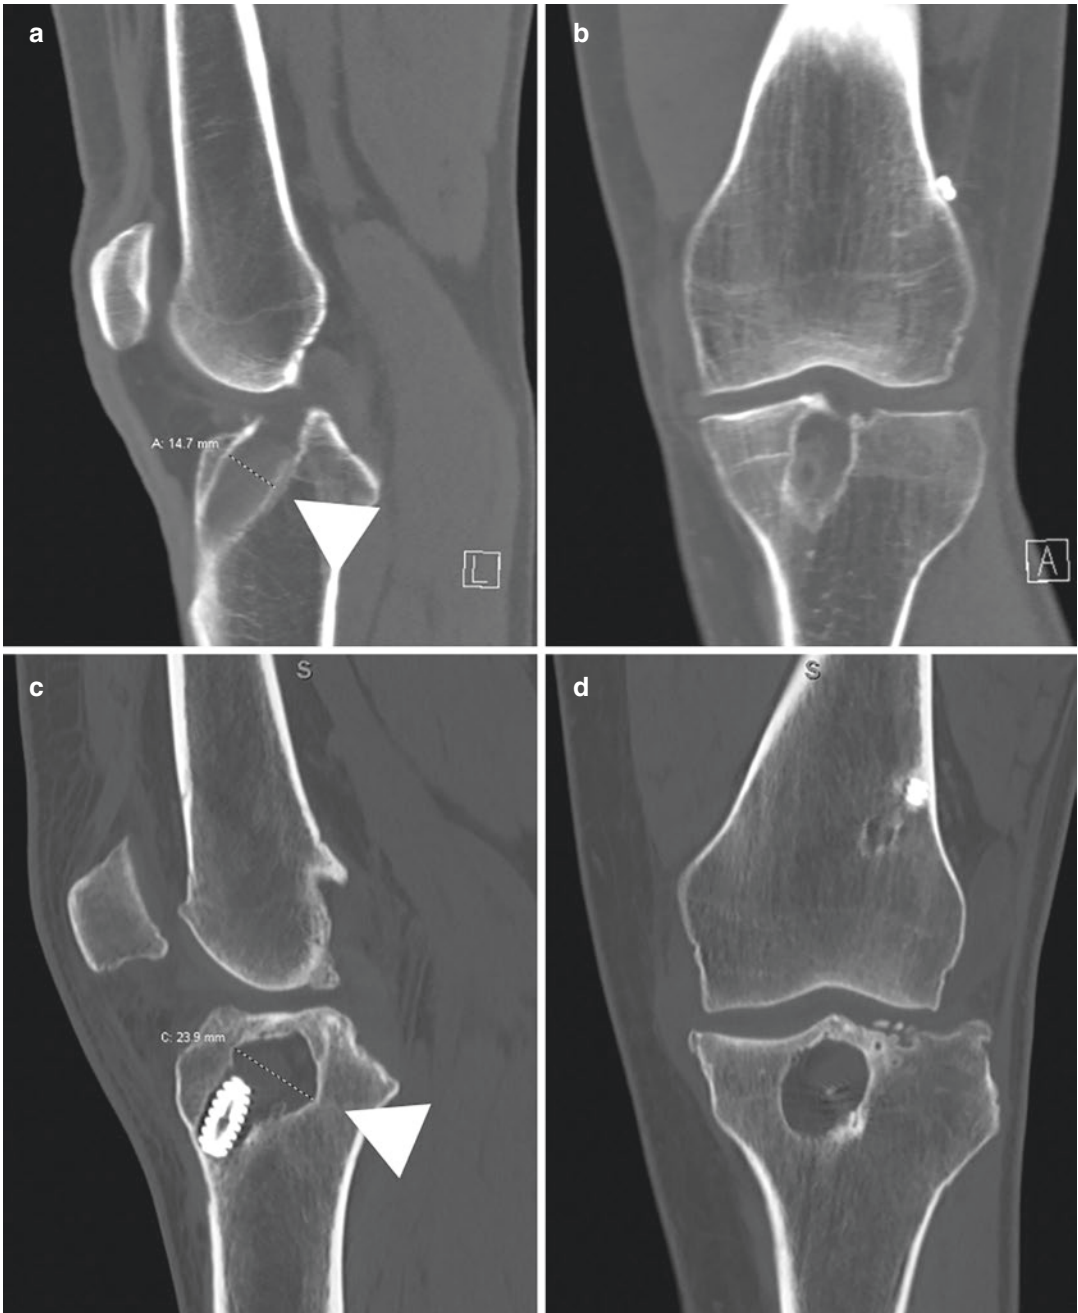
Tunnel osteolysis on CT after anterior cruciate ligament reconstruction. Sagittal (a and c) and coronal (b and d) images demonstrate examples of osteolysis of the tibial tunnel in two separate knees. Measurement of tunnels at their widest point are shown on the sagittal images
